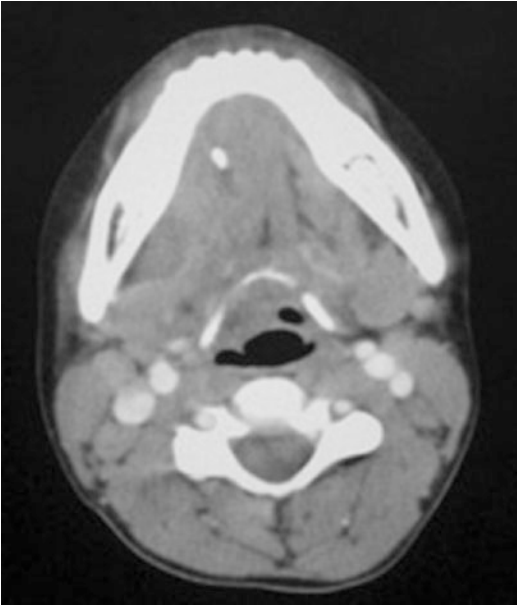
Axial CT imaging showing 5 mm stone with ductal dilation and floor mouth edema consistent with acute sialadenitis
